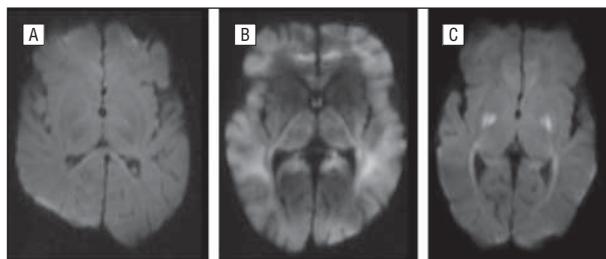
Appearance of hypoxic-ischemic encephalopathy on axial diffusion-weighted magnetic resonance imaging. A, A normal brain in a term newborn with no areas of restricted diffusion. B, Severely restricted diffusion in the basal ganglia and thalami, posterior limb of the internal capsule, and white matter. C, Focal restricted diffusion in the putamen and optic radiations.
